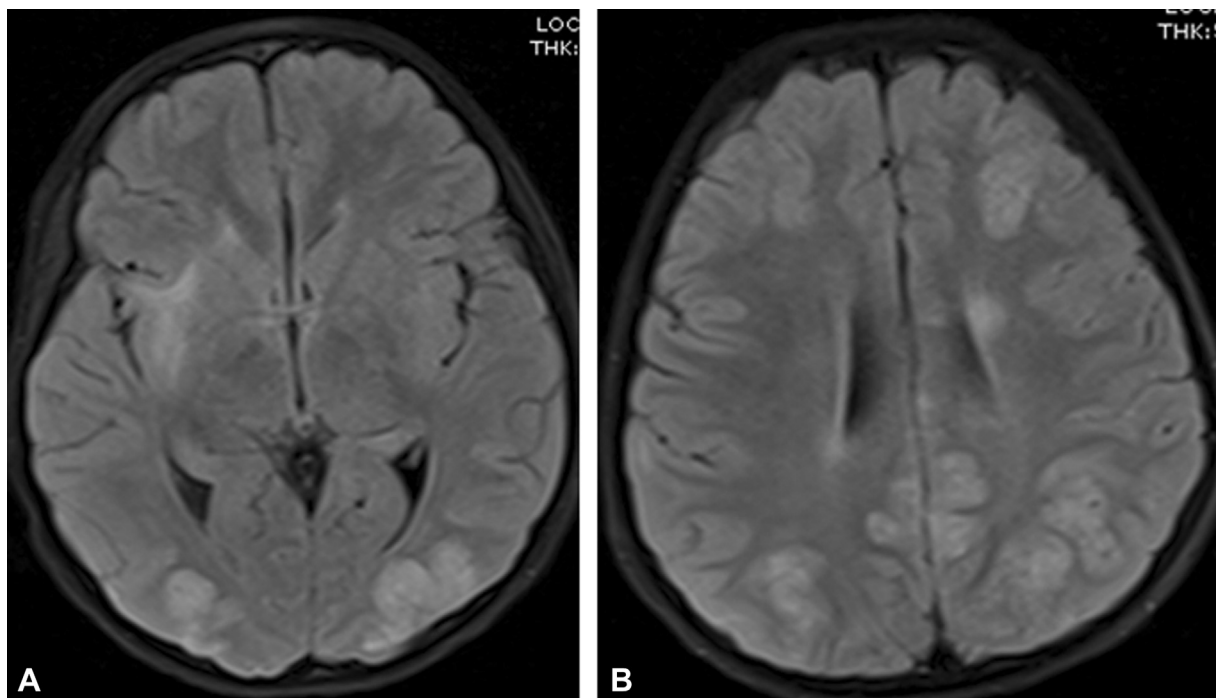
9-year-old with PRES. (A, B) Axial FLAIR images show multiple, confluent foci of T2 prolongation involving the cerebral cortex with involvement of the right subinsular white matter. There is preferential involvement of the posterior cerebrum. FLAIR, fluid-attenuated inversion recovery; PRES, posterior reversible encephalopathy syndrome.
